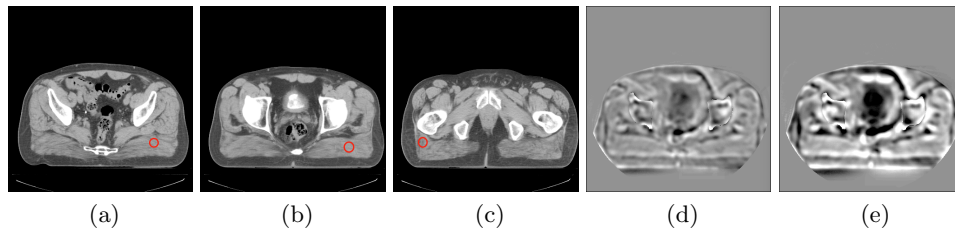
(a)-(c): Small regions containing similar types of muscle tissue, in different parts of the image, were used to estimate image uniformity. (d), (e) CBCT images corrected using downsampling factors of 2.0 and 4.0, respectively subtracted from that corrected without downsampling.
